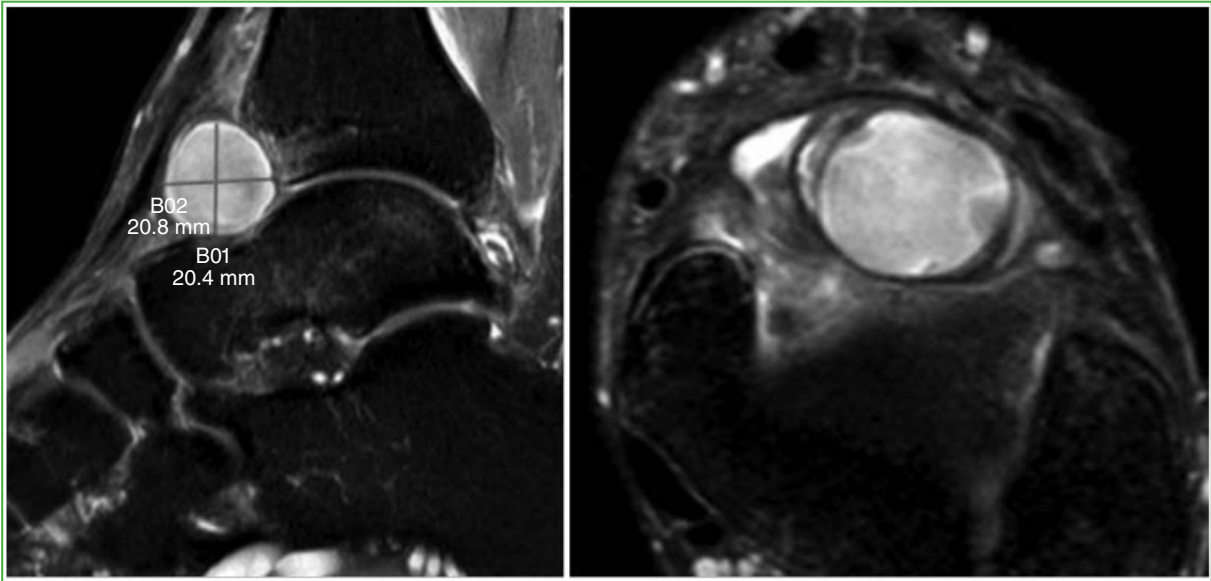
Magnetic resonance imaging of the ankle, sagittal and axial images. Pseudoaneurysm of the anterior tibial artery measuring 21 x 22 mm (green lines).
